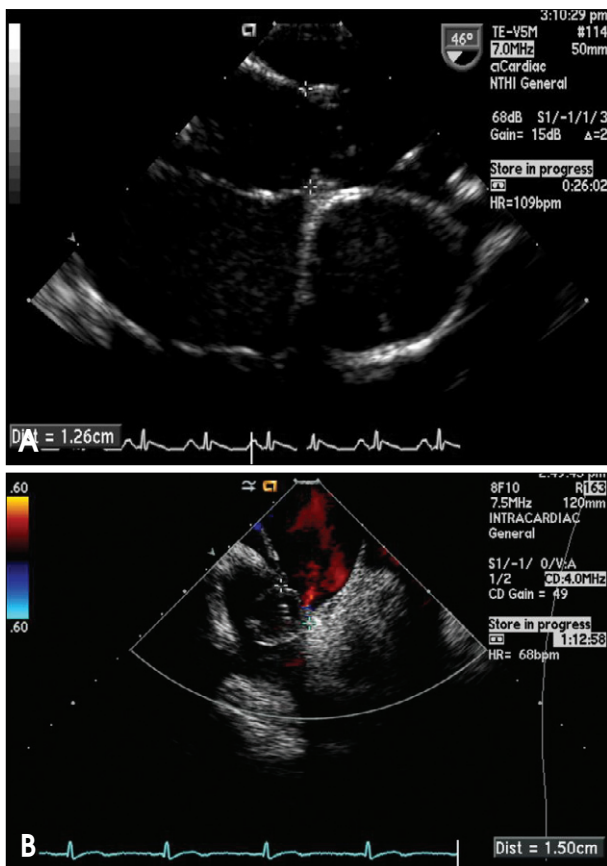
The echocardiographic finding of balloon sizing for the ASD device. A: The TEE finding revealed the stretched balloon diameter with “waist” across ASD measured. Sometimes this method had the risk of oversizing. B: The ICE finding revealed the occlusive balloon diameter without waist across ASD measured. When color Doppler was disappeared by the occlusive balloon, the balloon size was measured.
